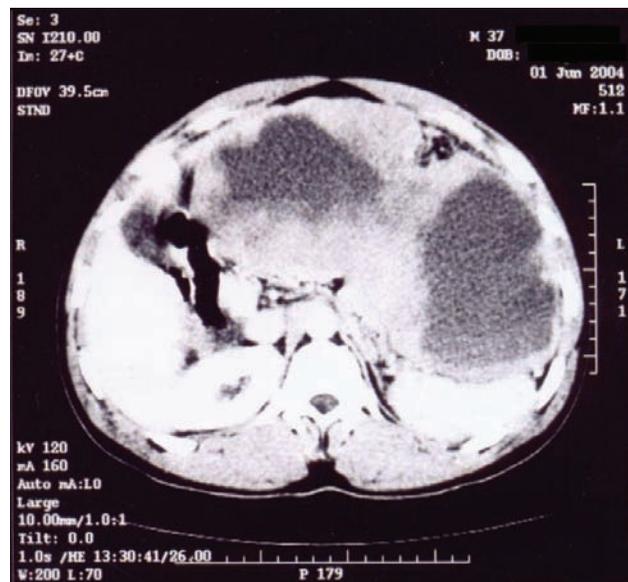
Computed tomography of the abdomen showed a 23 cm × 20 cm × 10 cm necrotic mass in close contact with the left lobe of the liver.
